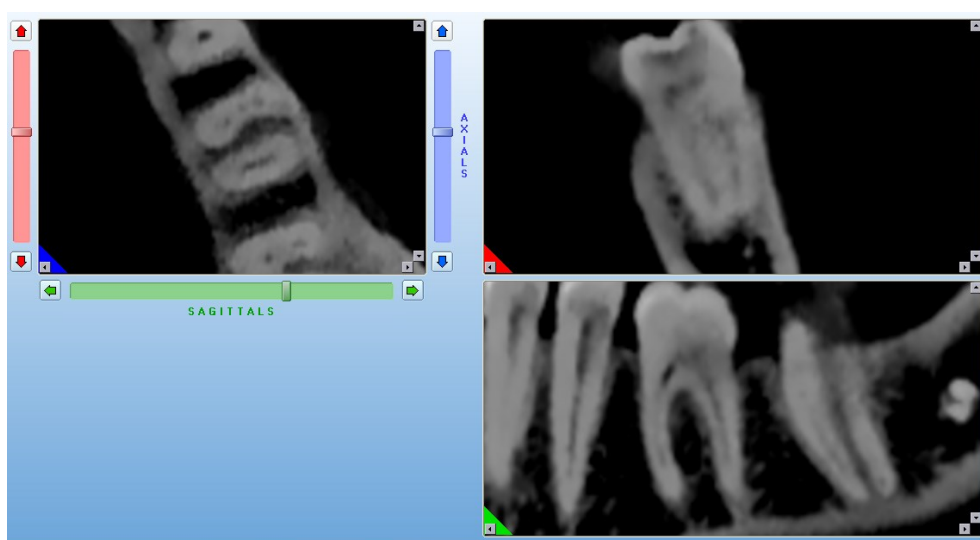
Axial, coronal and sagittal view of CBCT image, showing middle mesial canal
